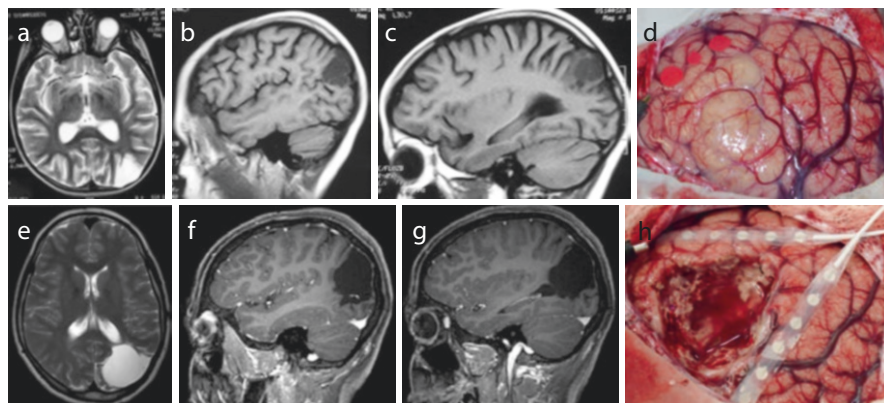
Case of a 7-year-old boy with daily seizures since the age of 1 year and 6 months, characterized by oculocephalic version to the right followed by right hemiclonicus, loss of consciousness, and manual automatisms. (a–d), preoperative MRI scans and tumor at surgery, respectively. (e–h), respectively, postoperative MRI scans and tumor site after resection. Pathology: dysembryoplastic neuroepithelial tumor (DNET) and cortical dysplasia type III b
